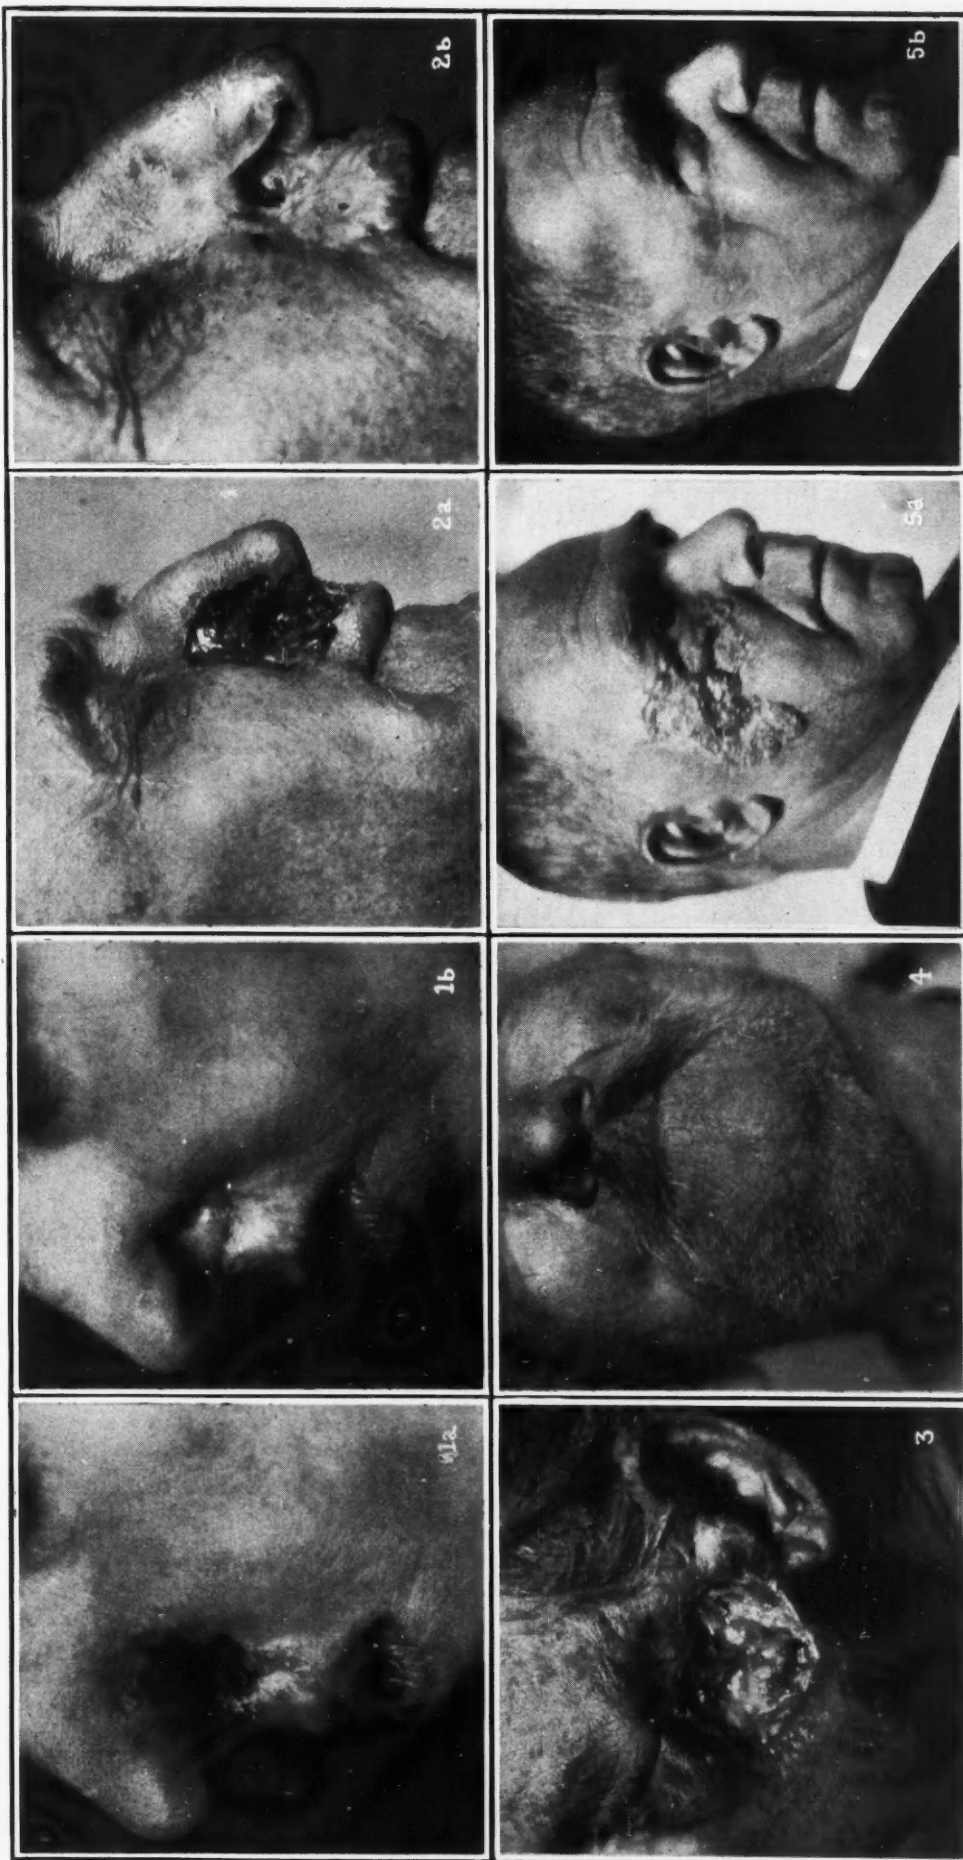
(a)—This lesion had been repeatedly cauterized and had been treated by both x-rays and radium without success. The result is loss of tissue and cellular changes, making subsequent success more difficult.
